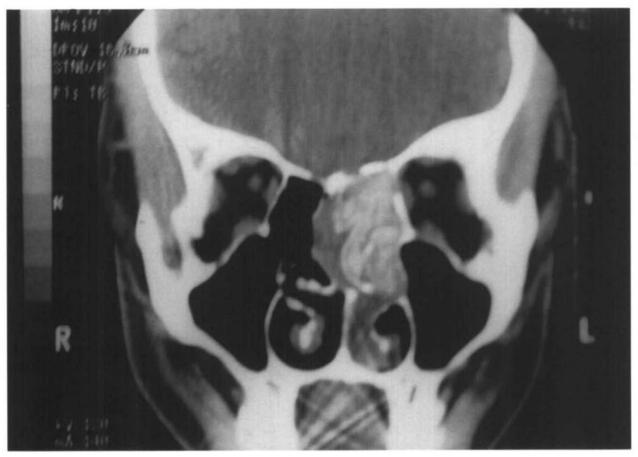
CT scan of left ethmoid AFS. Expanding inspissated fungal debris has caused deviation of the adjacent lamina papyracea and nasal septum. The heterogenous opacification typical of fungal sinusitis is present.
